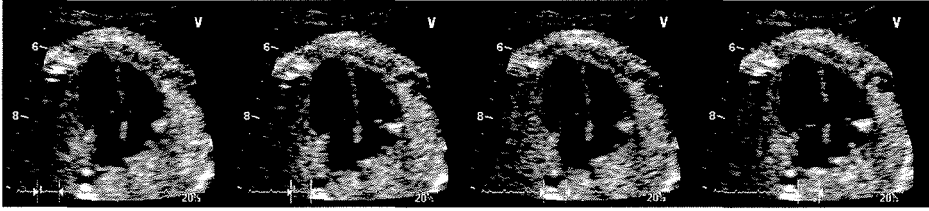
Visual control of gating accuracy: Four different cine-loops from the same recording are running synchronized, based on the tissue Doppler gating signal. The snapshot is taken 50 ms after maximal relaxation, as the atrioventricular valves are closing.
